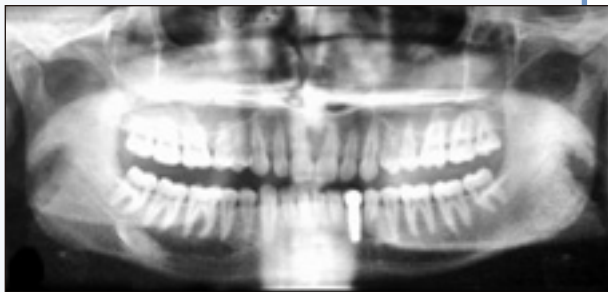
Panoramic radiograph showing the transmigrated tooth 33 apical to the mesial aspect of tooth 48.
